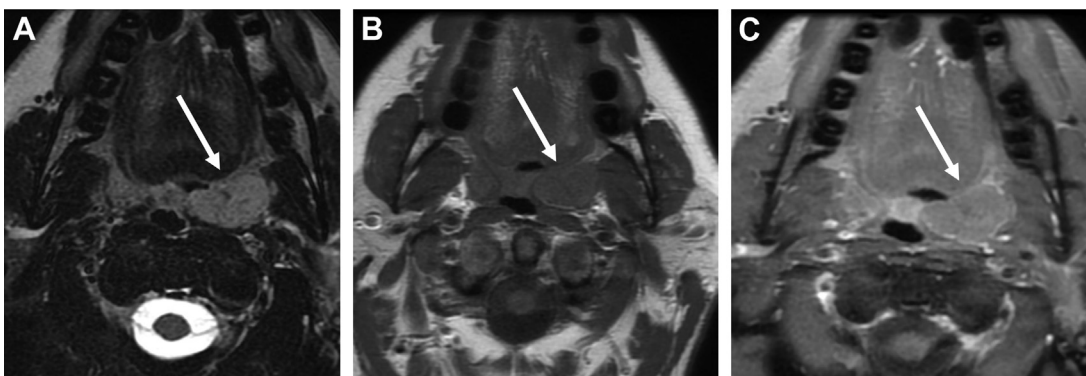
MR imaging characteristics of squamous cell carcinoma. (A) Axial T2WI shows a left tonsillar carcinoma, which is a high signal. The lesion has T1 intermediate signal (B) and homogeneously enhances on fat-suppressed contrast-enhanced T1-weighted (T1W) sequences (C) (arrows).
